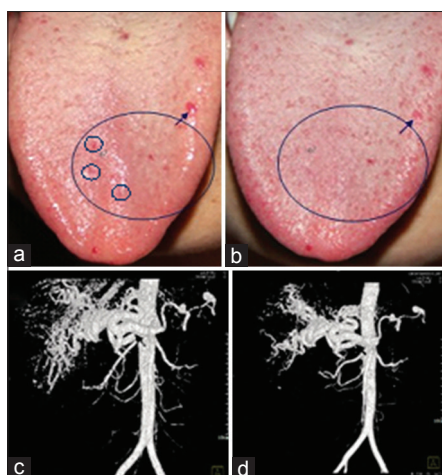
Telangiectasia images of case two with hereditary hemorrhagic telangiectasia. (a) Multiple mucocutaneous telangiectasia on the nose (before thalidomide therapy); (b) 6 months after thalidomide therapy; (c) the image of hepatic CTA (before thalidomide therapy); and (d) the image of hepatic CTA for 6 months after thalidomide therapy; the hepatic proper artery proximal transverse diameter is 125 mm, which is smaller than before thalidomide therapy (130 mm). Arrows show the hepatic proper artery proximal.
